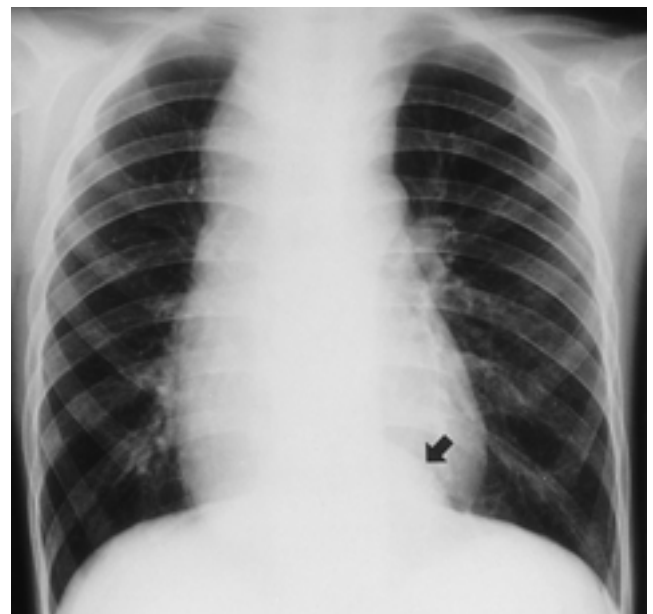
Simple chest PA radiograph shows smooth lobulated contour of mediastinal mass bilaterally. Round smooth mass density is seen on left retrocardia space (arrow).
